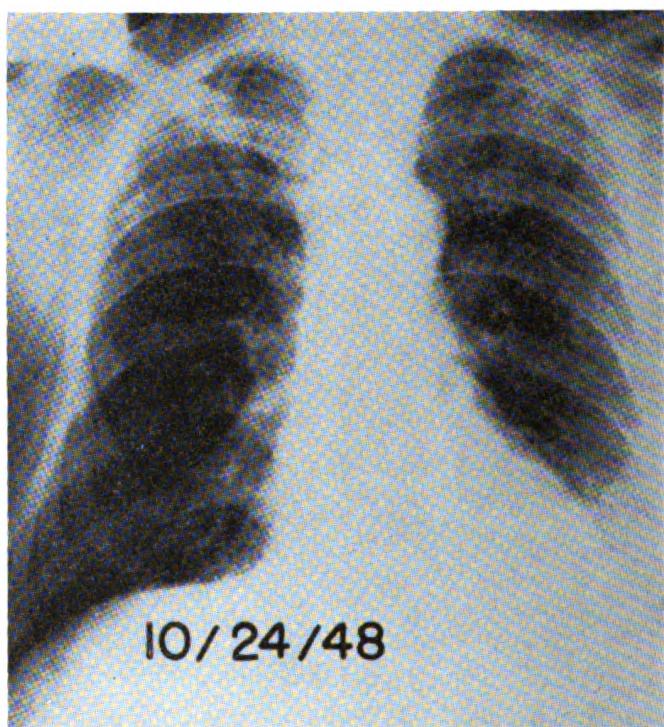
Anteroposterior view of chest in Case E.H. two months after stopping testosterone and X-ray therapy, showing further involvement of medial $\frac{1}{3}$ of left clavicle.
